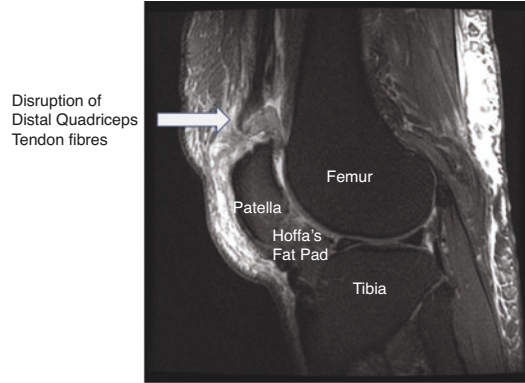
MRI – T2 sagittal – full thickness quadriceps tendon tear
